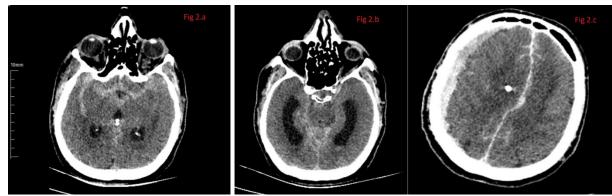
CT scan showing subarachnoid hemorrhage, hydrocephalus, and subdural hematoma post-intervention. (a) Cranial CT scan showing subarachnoid hemorrhage in the basal cisterns; (b) Ventricular enlargement indicating hydrocephalus requiring EVD; (c) Post-EVD imaging showing acute subdural hematoma.
